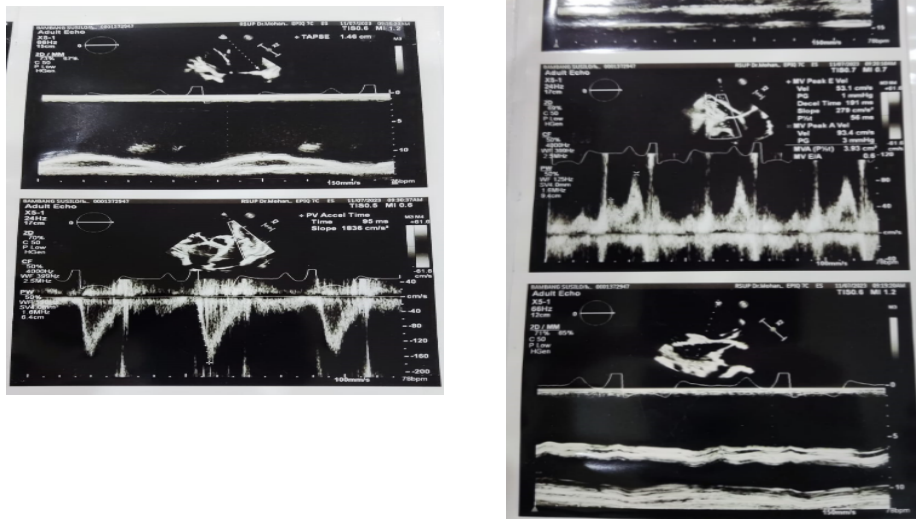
Echocardiography RSMH November 7, 2023
